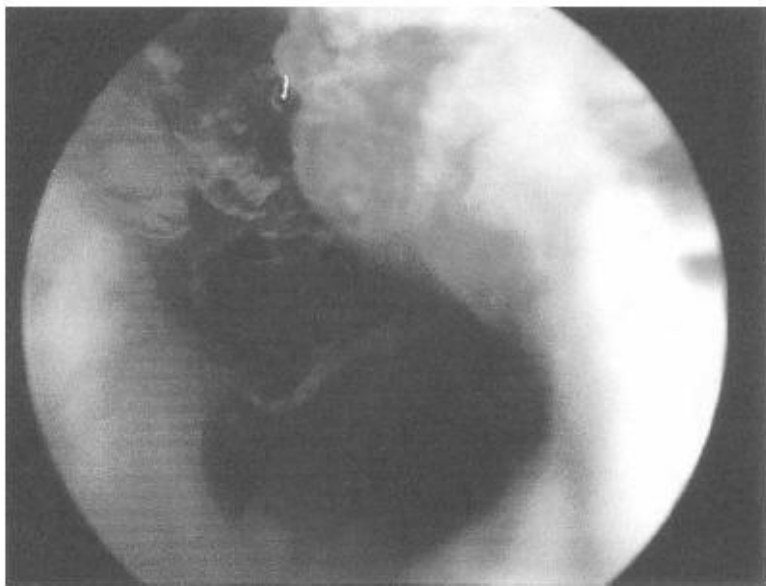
Hysteroscopic view of interior of patient's uterus during removal of the left cornual ectopic gestation under sonographic guidance.
